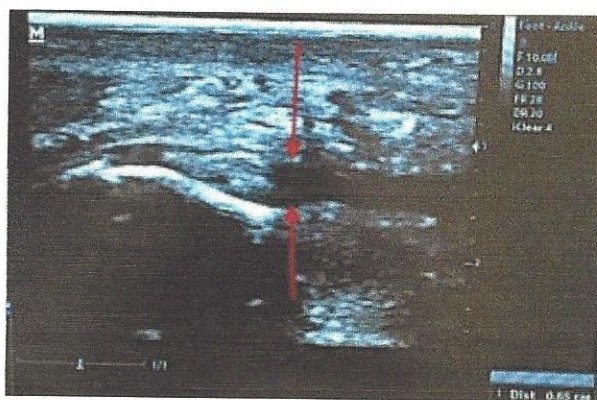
Sagittal ultrasound of the heel at the origin of the plantar fascia showing thickened fascia (arrows)
